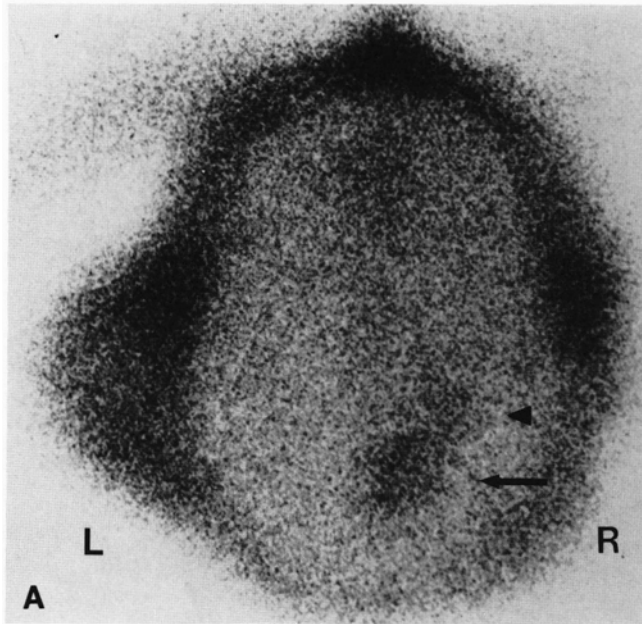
(A) Four month post-surgery ^{201}Tl scan. Region of increased ^{201}Tl uptake (arrow) is seen posterior and medial to the original tumor site (arrowhead). (B) Four month post-surgery contrast enhanced CT scan fails to show an abnormality in the region of tumor recurrence.
